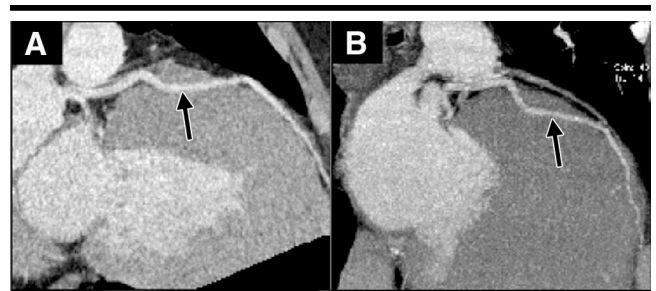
Coronary myocardial bridge at four-detector row CT. *A*, Craniocaudal curved multiplanar reconstruction and, *B*, thin right anterior oblique maximum intensity projection in a symptomatic patient demonstrate intramyocardial course (arrows) of middle portion of the otherwise normal-appearing LAD coronary artery. The overlying myocardium represents the bridge.
